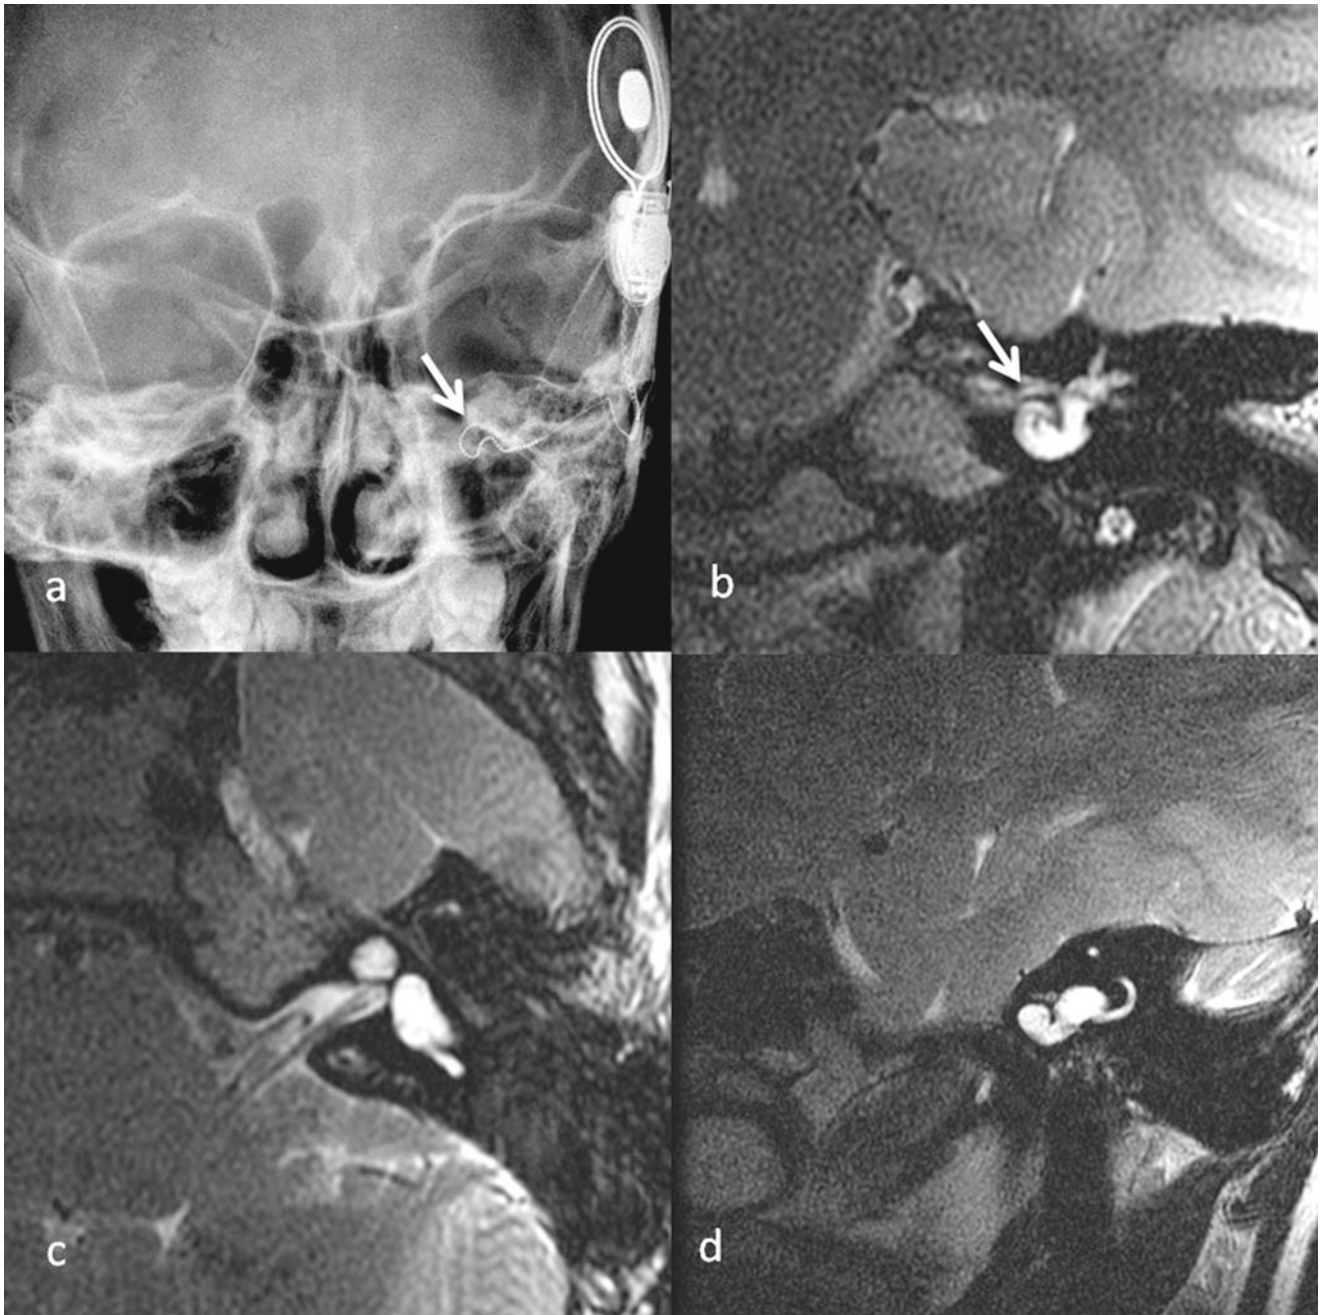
Incomplete partition type 1 (IP-1) malformation. (a) Frontal plain postoperative radiograph with atypical appearance of CI electrode array (*arrow*). This finding is due to abnormal cochlear anatomy demonstrated by MRI T2 (b) coronal, (c) axial and (d) sagittal sections.
